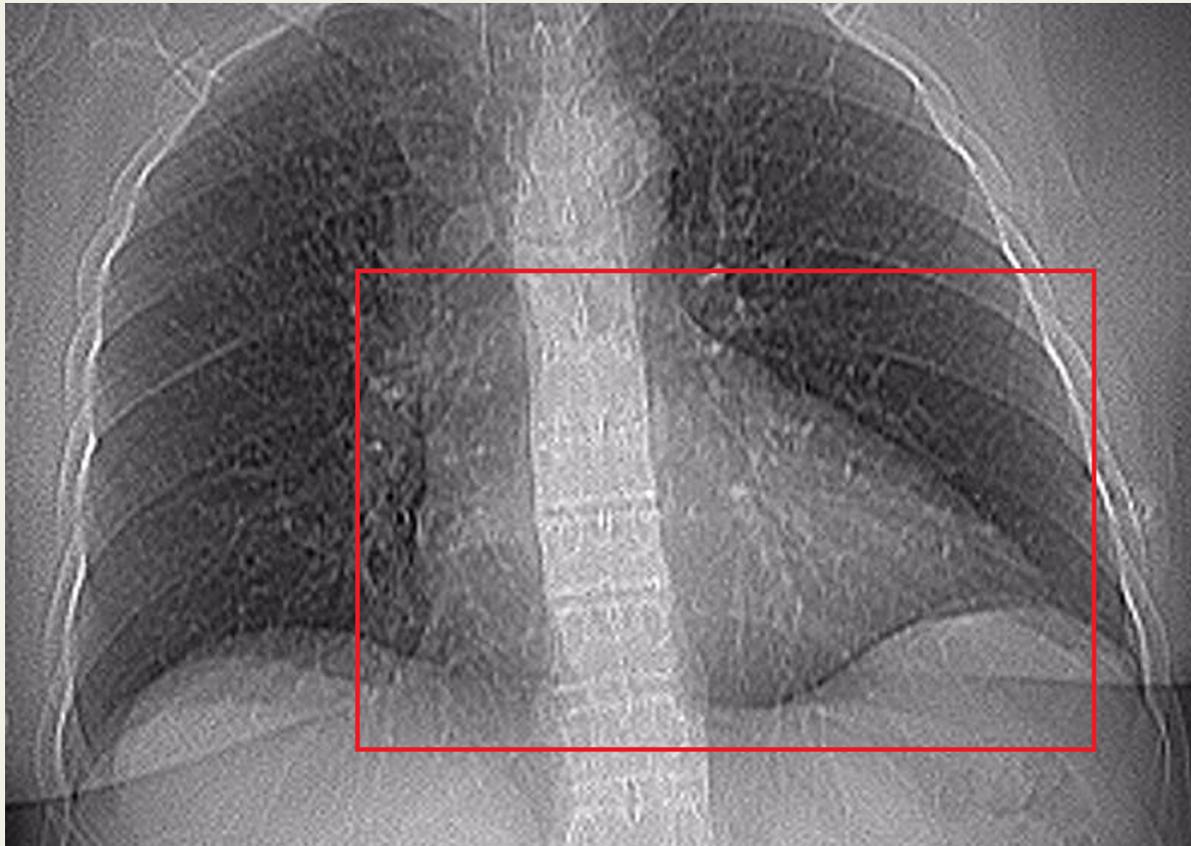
CT scout with Full FOV and approximating Limited FOV (red square).
